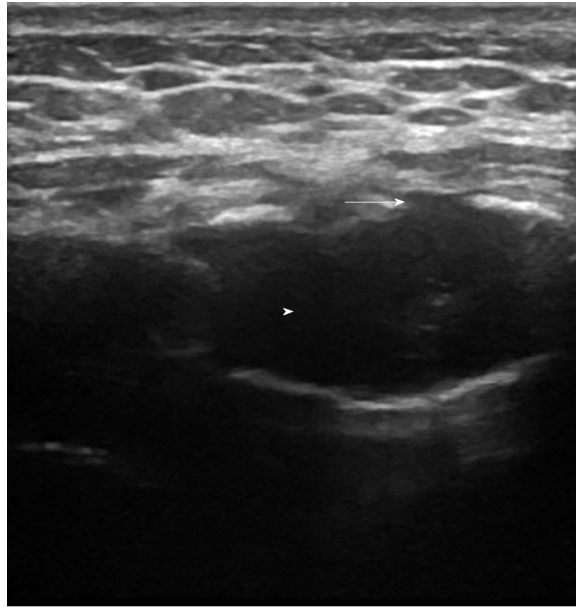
Ultrasound of sternum showing cortical irregularities (arrow) with central hypoechoic area (arrow head).
